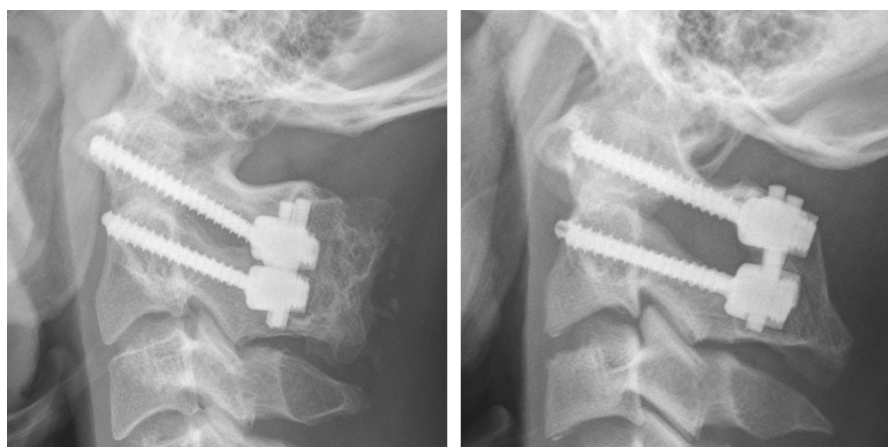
Lateral radiographs showing C1 lateral mass screws (Left) and C1 posterior arch screws (Right).
